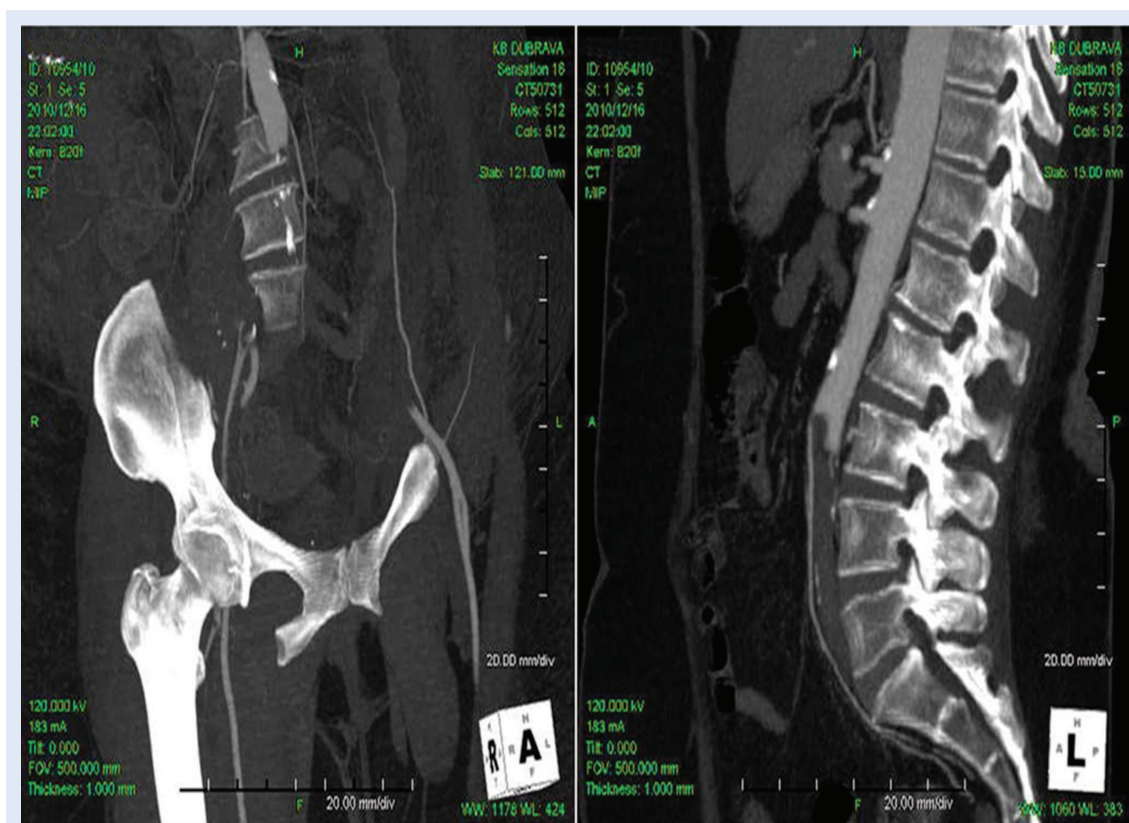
Multi-slice CT (coronal and sagittal plane): total occlusion of the infrarenal segment of the abdominal aorta with complete occlusion of both common iliac arteries, right profunda femoral artery and right distal superficial femoral artery.
